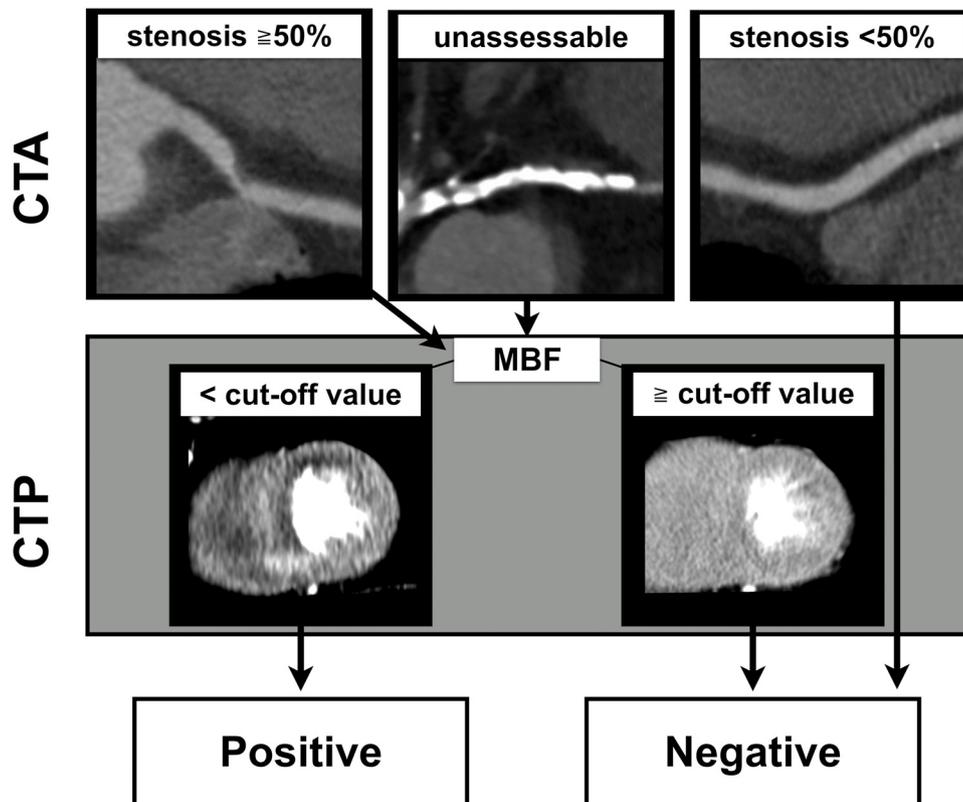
Diagnostic algorithm for integrated assessments with computed tomography angiography and computed tomography perfusion. CTA, computed tomography angiography; CTP, computed tomography perfusion; MBF, myocardial blood flow.
